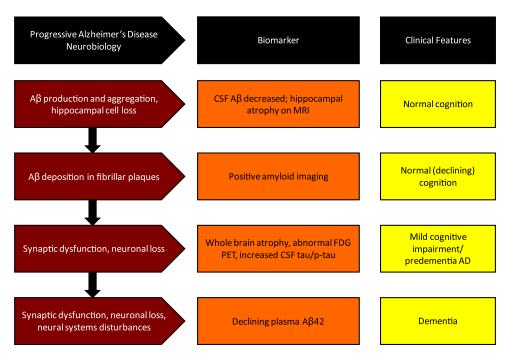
Putative sequence of events in AD; the neurobiology changes over time as reflected in the biomarker profile and the clinical state of the patient (Aβ, amyloid beta protein; AD, Alzheimer's disease; CSF, cerebrospinal fluid; FDG-PET, fluorodeoxyglucose positron emission tomograph; MRI, magnetic resonance imaging; p-tau, phospho-tau).
